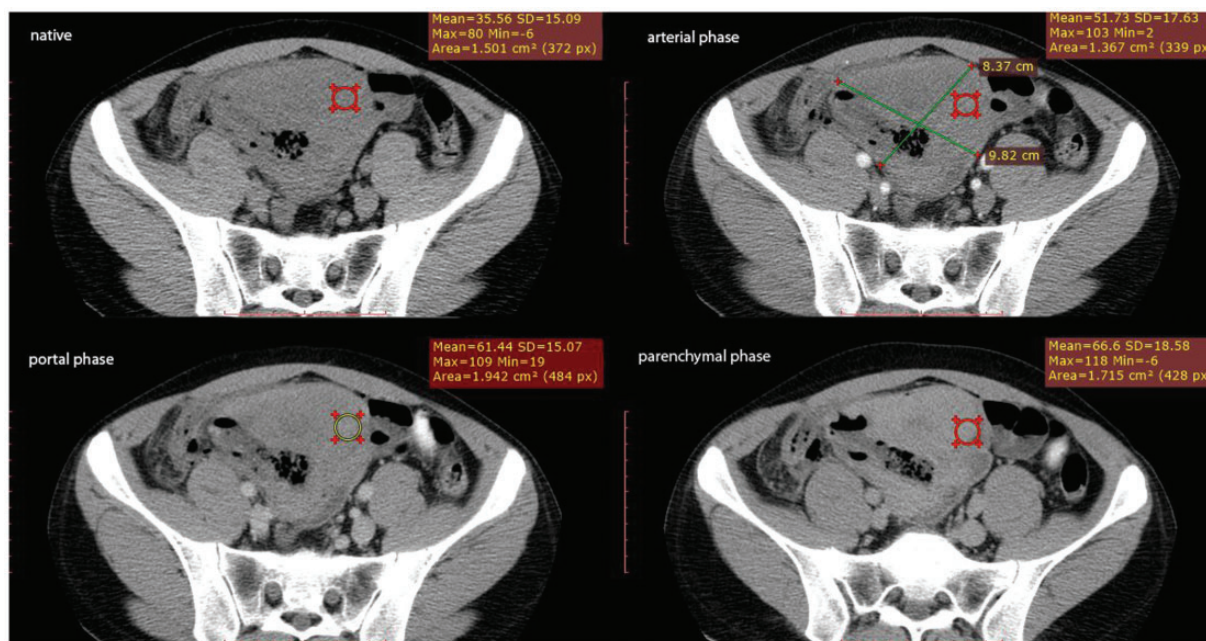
Computed tomography. A well-demarcated soft-tissue mass with gradual enhancement is visible on contrast-enhanced CT.
